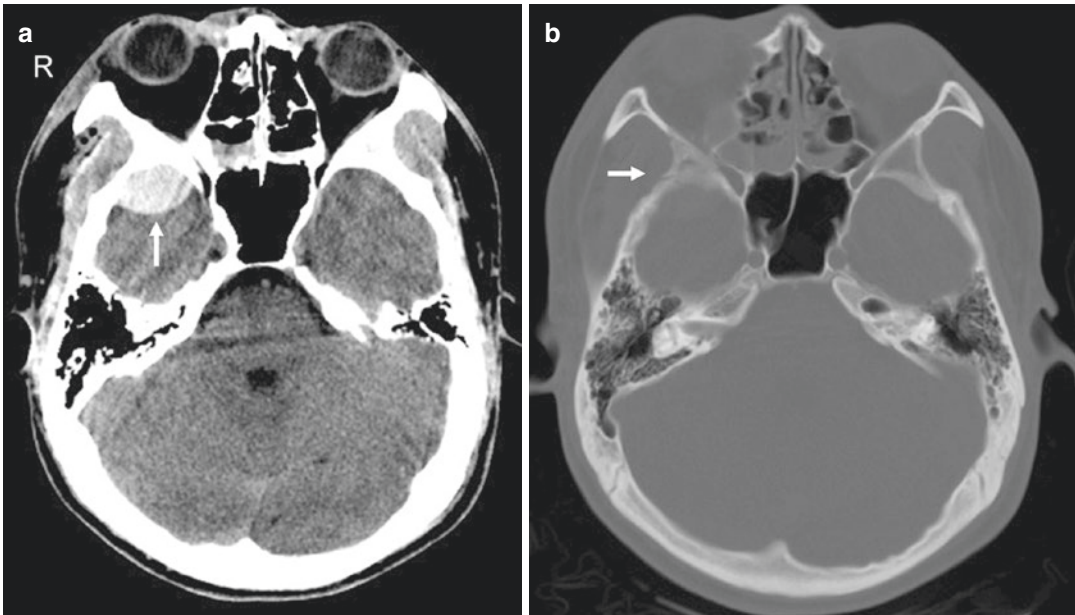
Venous EDH. (a) Axial CT image shows a biconvex, homogeneous, high attenuation extra-axial collection within the right middle cranial fossa (*vertical arrow*). (b) CT image displayed in “bone window” reveals a fracture
